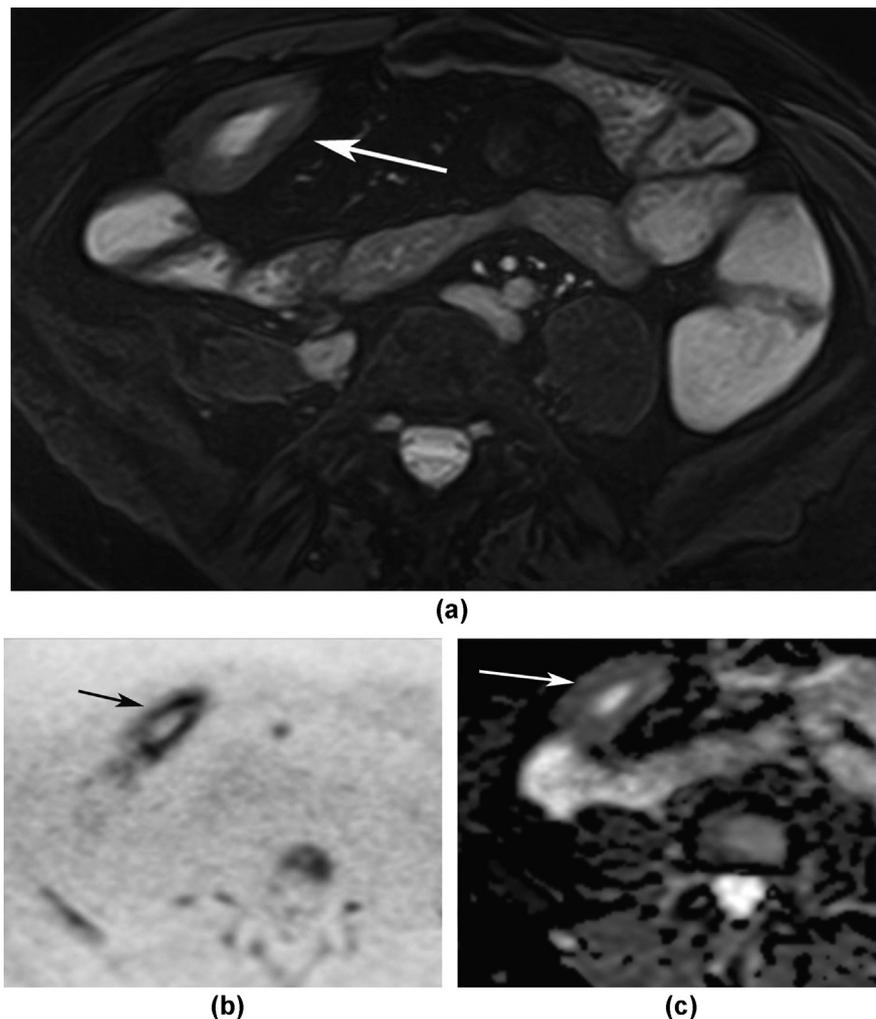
DW-MR imaging. (a) Axial True-FISP image in 39-year-old male patient with marked thickening and inflammation of the ileum (arrow). (b) Axial DW-MR image shows increased signal at the site of inflammation. (c) ADC map shows hypointense signal in the affected segment (arrow).
